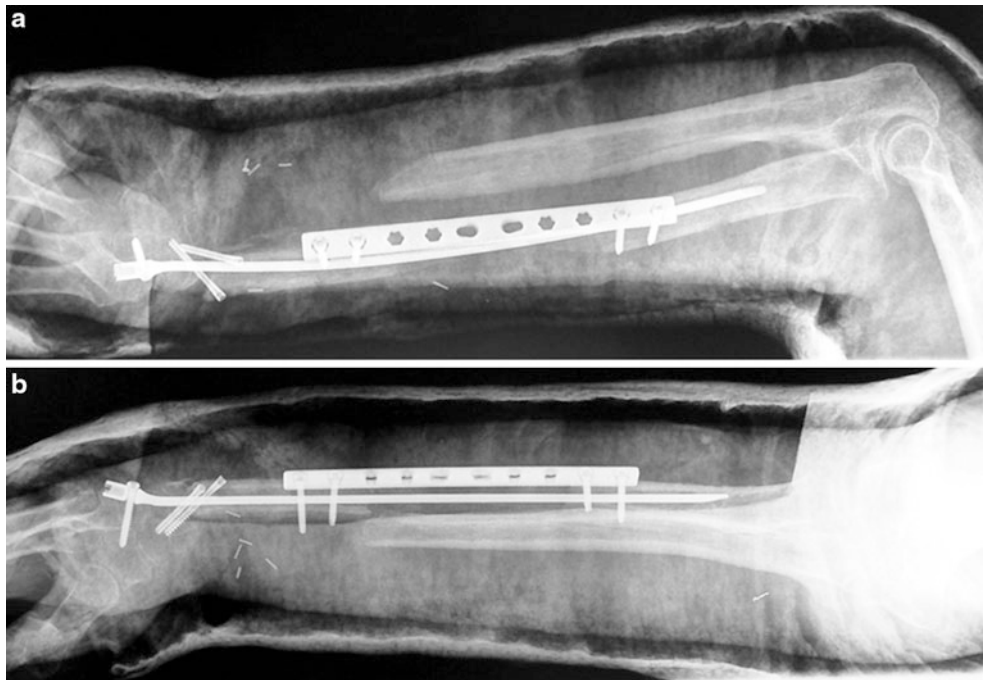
Following ossification of the regenerate, the nail was removed, and a wrist arthrodesis plate was used to achieve solid union between transported segment and carpal bones. AP (a) and Lat (b) X-rays
